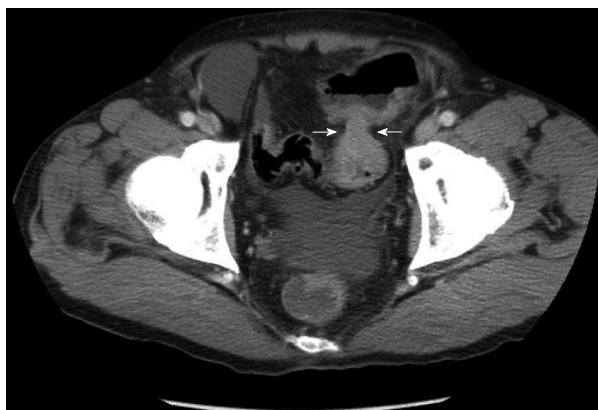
Computed tomography revealed sigmoid colon cancer. The white arrows indicated the site of stenosis due to the cancer.
